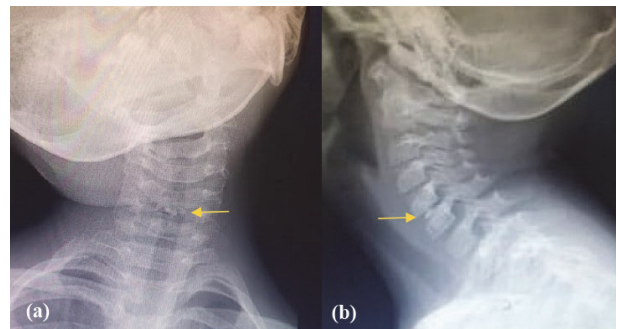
Cervical anterior-posterior (a) and lateral (b) radiographs. The arrow pointing to the calcified density lesion found at the C5-C6 level.
